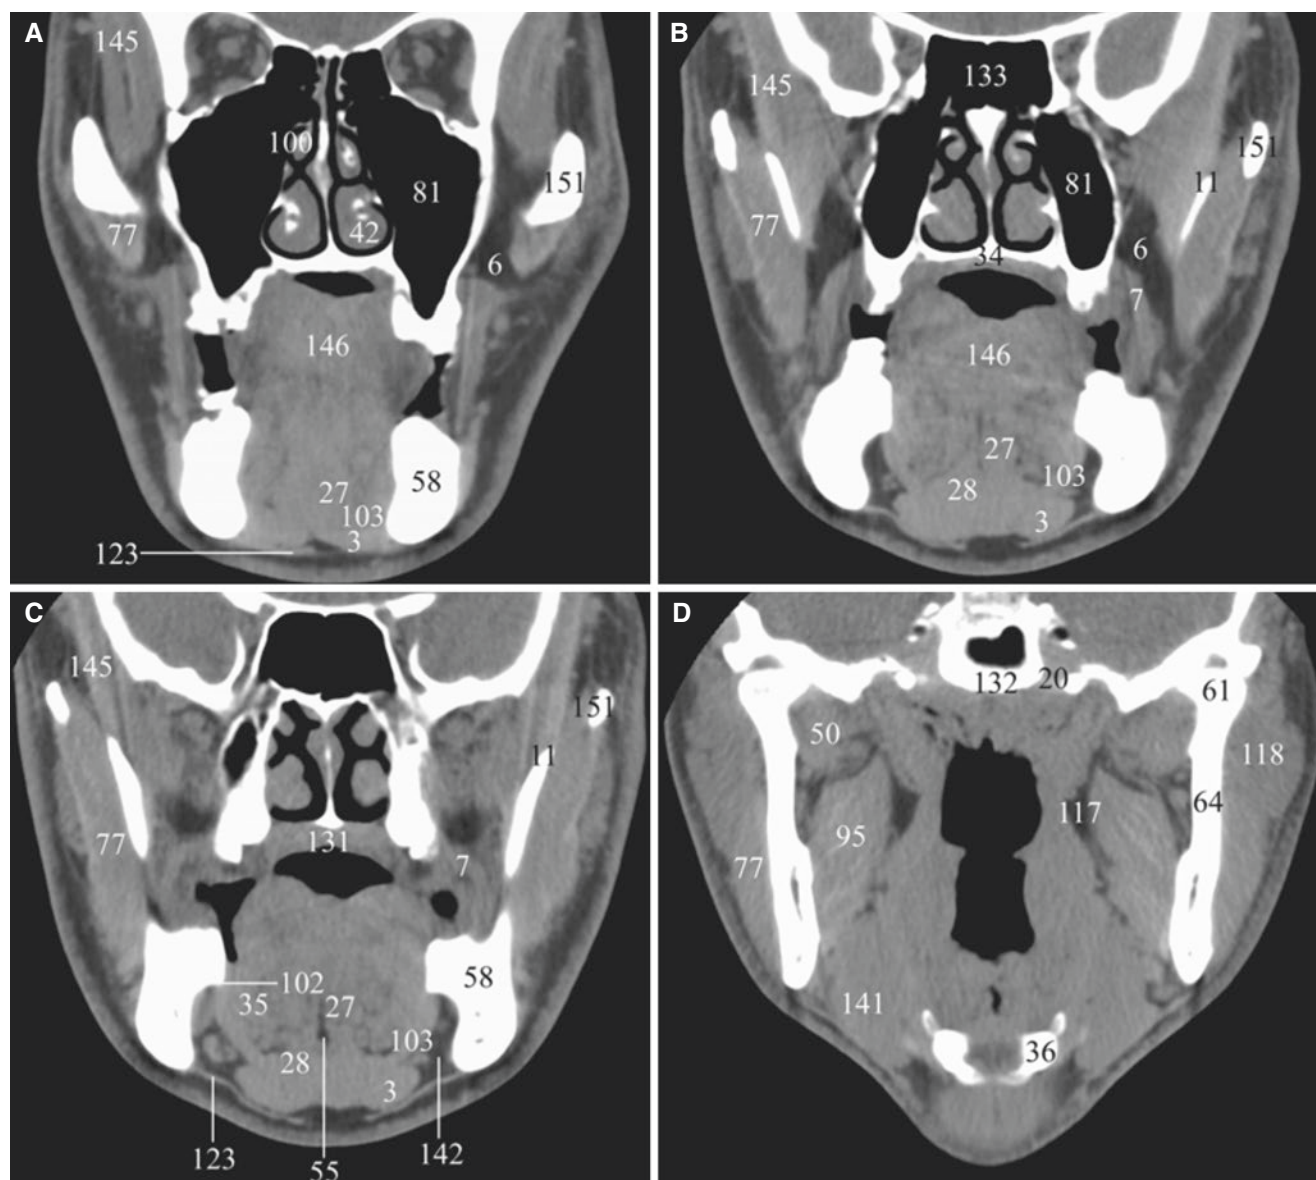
Normal soft-tissue anatomy of the face; coronal CT images from anterior (A) to posterior (D)
